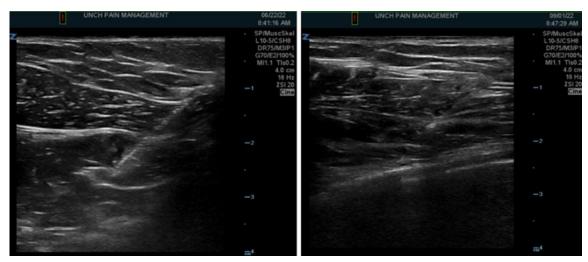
Injections of the right pectoralis minor muscle under ultrasound-guided inplane visualization. Left: 06/22/22: patient's initial diagnostic pectoralis minor muscle injection with 0.75 mL of 0.25% bupivacaine injected at 2 locations within the muscle. Right: 09/01/22: patient's first therapeutic BoNT injection with 40 U with 1 mL of 1% lidocaine injected at 2 locations (20 U/0.5 mL in each location). BoNT, botulinum neurotoxin; U, unit.
